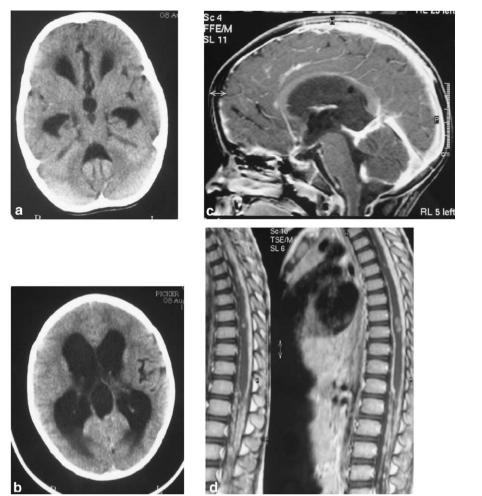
a and b Cerebral CT images at that time of the first clinical manifestation in June 2004, no intracranial lesion was evident, only a communicating hydrocephalus. c Cranial metastatic spread at the time of the intramedullary tumor progression along the ventricles as well as frontobasally is depicted in sagittal images. d The initial intramedullary tumor at T8/9 is shown on sagittal T₁-weighted contrast-enhanced MR images from July 2004.
